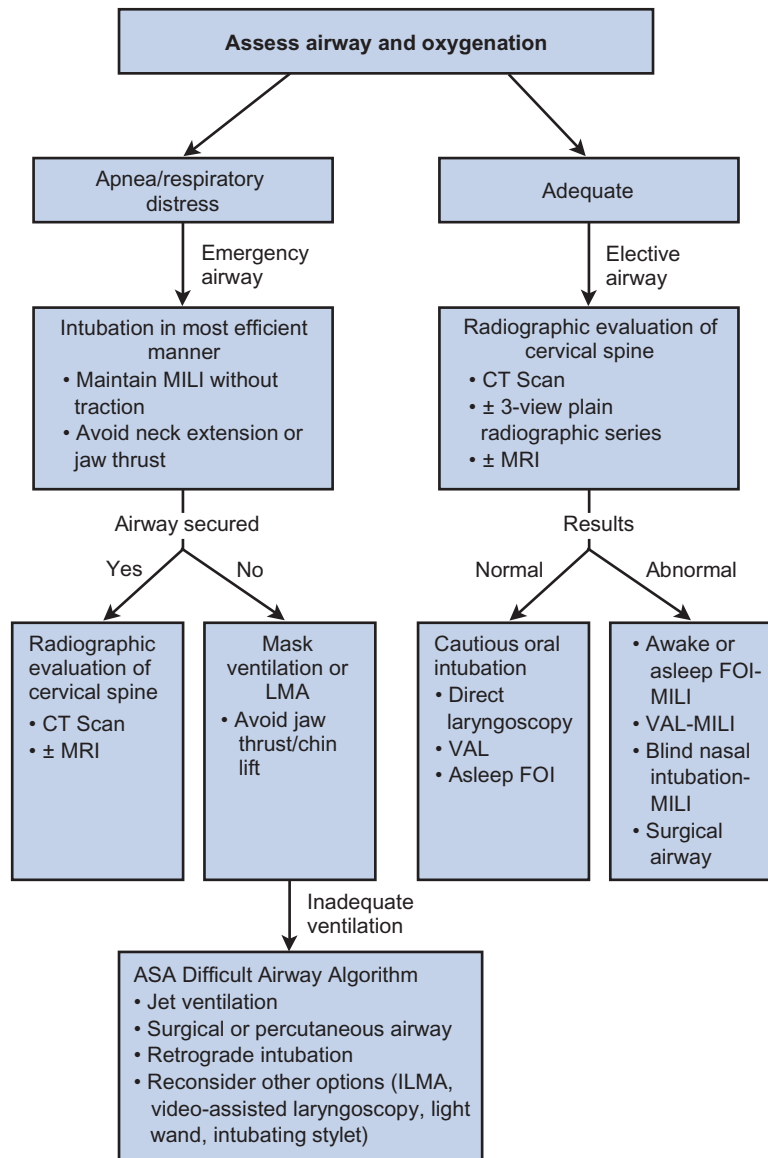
Suggested airway management algorithm for a patient with a suspected cervical spine injury. ASA, American Society of Anesthesiologists; CT, computed tomography; LMA, laryngeal mask airway; MRI, magnetic resonance imaging; FOI, fiberoptic intubation; ILMA, intubating laryngeal mask airway.
